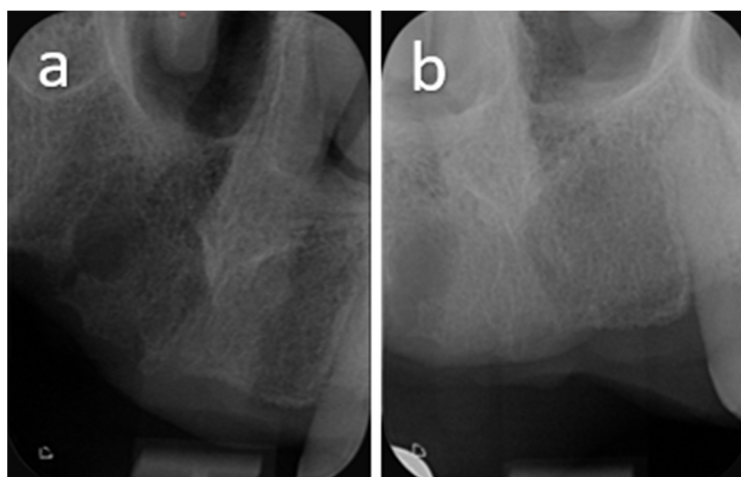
One-year postoperative follow-up x-ray showing partial ossification at site 12 (a) and complete ossification at median site (b).
